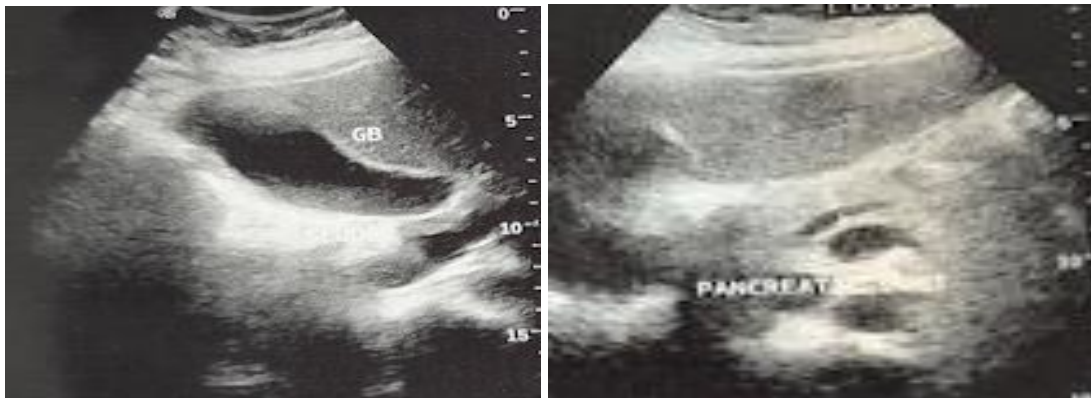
Image Shows a 50-year-old female with ultrasound features of gall bladder sludge and a dilated main pancreatic duct.
